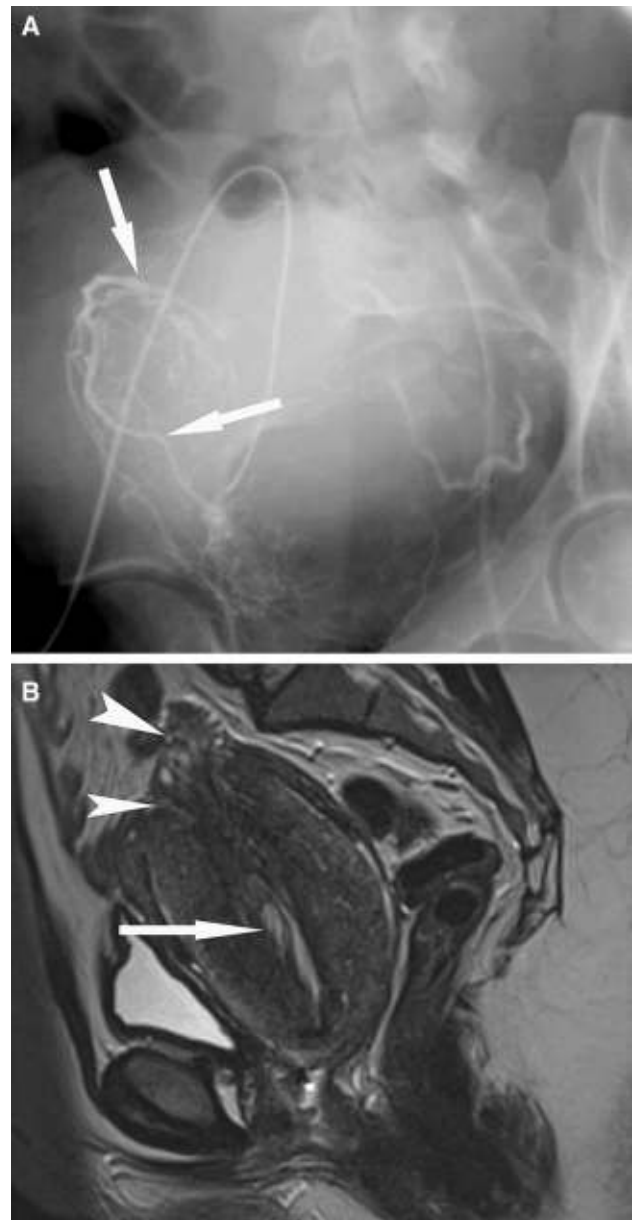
A 30-year-old woman with primary postpartum hemorrhage due to uterine inversion. A Selective angiogram of right uterine artery in right anterior oblique projection shows right uterine artery (arrows). The uterine artery is abnormally displaced compared to the usual appearance. B Magnetic resonance imaging obtained in the sagittal plane shows uterine pedicle in central location (arrow), and the cervix is at the superior aspect of the uterus (arrowheads), thus confirming uterine inversion
